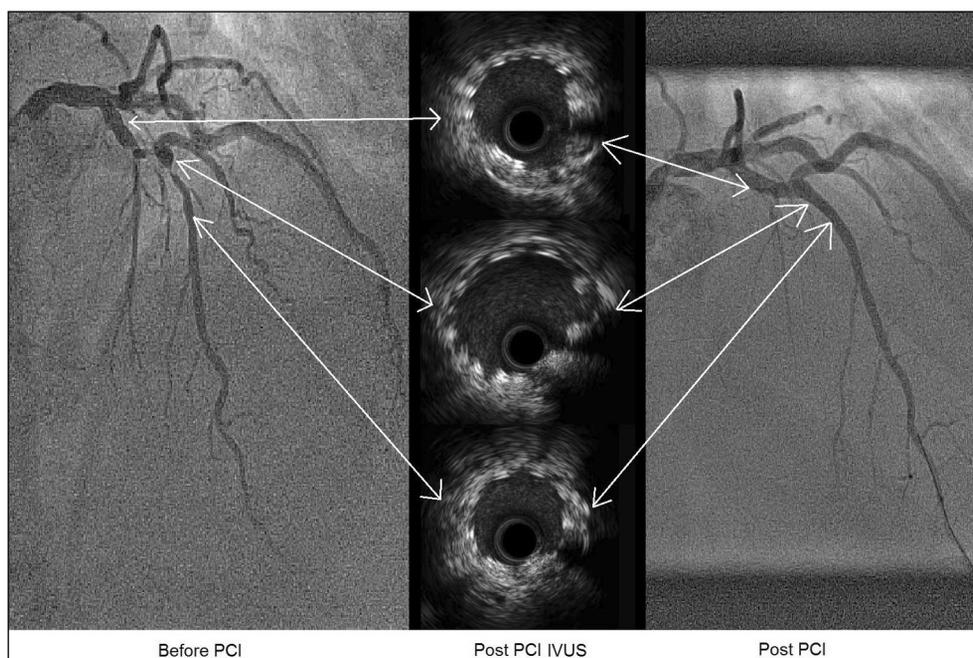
STENTYS® stent implantation with intravascular ultrasound (IVUS) images recorded after stent deployment; PCI — percutaneous coronary intervention
